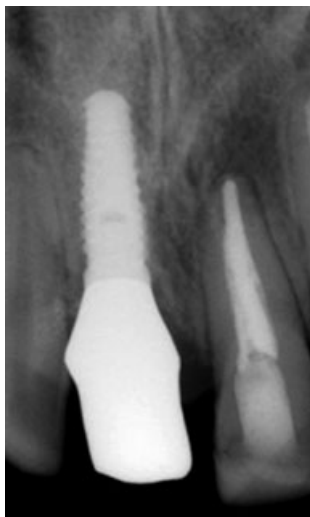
Radiograph of the implant and final restoration.
